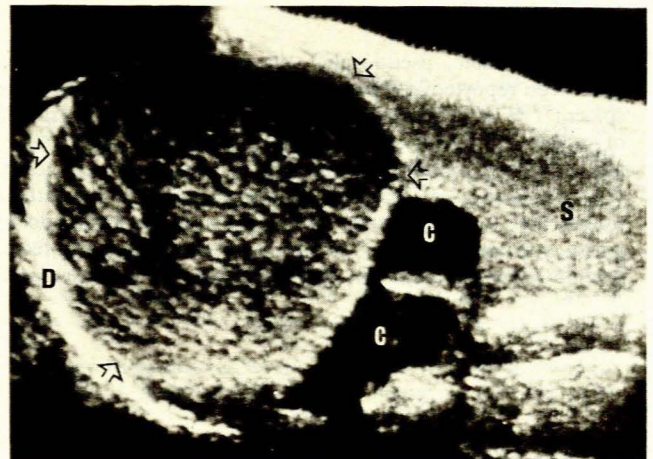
Case 1. Longitudinal ultrasonogram through spleen (S) revealing a large pseudosolid simple cyst with well-defined rim (arrows) in its upper pole (Cs — two smaller cystic lesions; D — diaphragm).
